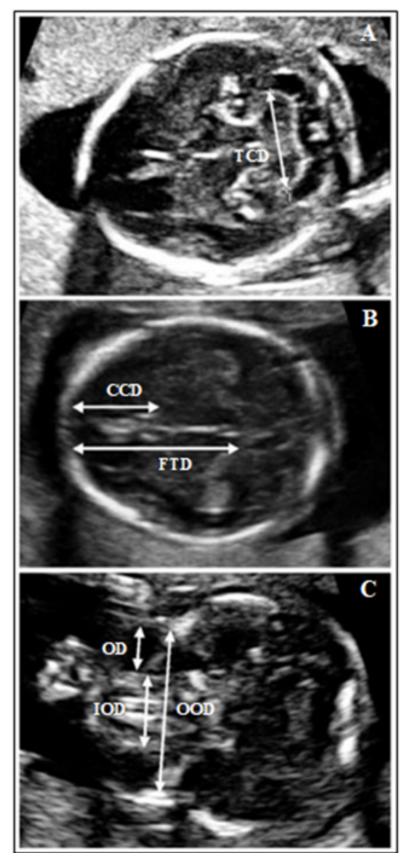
Prenatal ultrasound showing axial view of the calvaria with markers annotated. Obtained from: (11)
